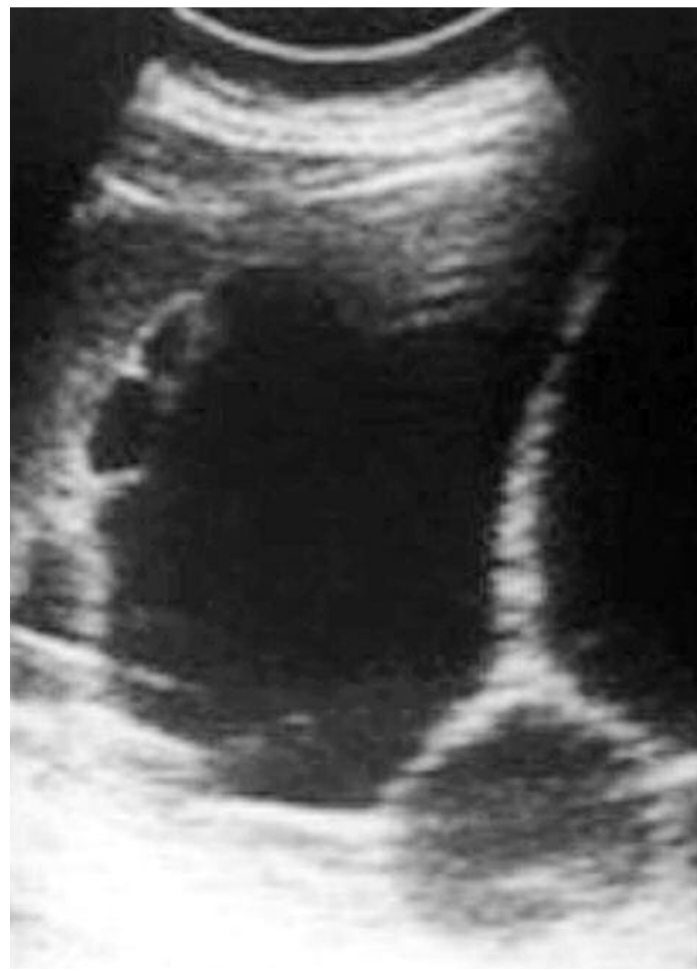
Ultrasonogram of the breast revealing a rounded lesion with internal septations and heterogeneous echogenicity.
